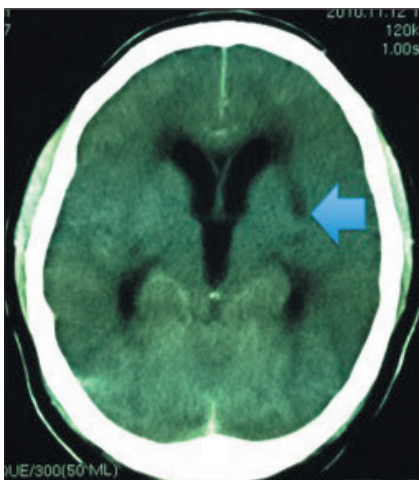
CT scan – patient with TBM and hydrocephalus. Note the small infarct in the left internal capsule. This is as a result of the vasculitis associated with TBM. The infarct is indicated by the small arrow.
